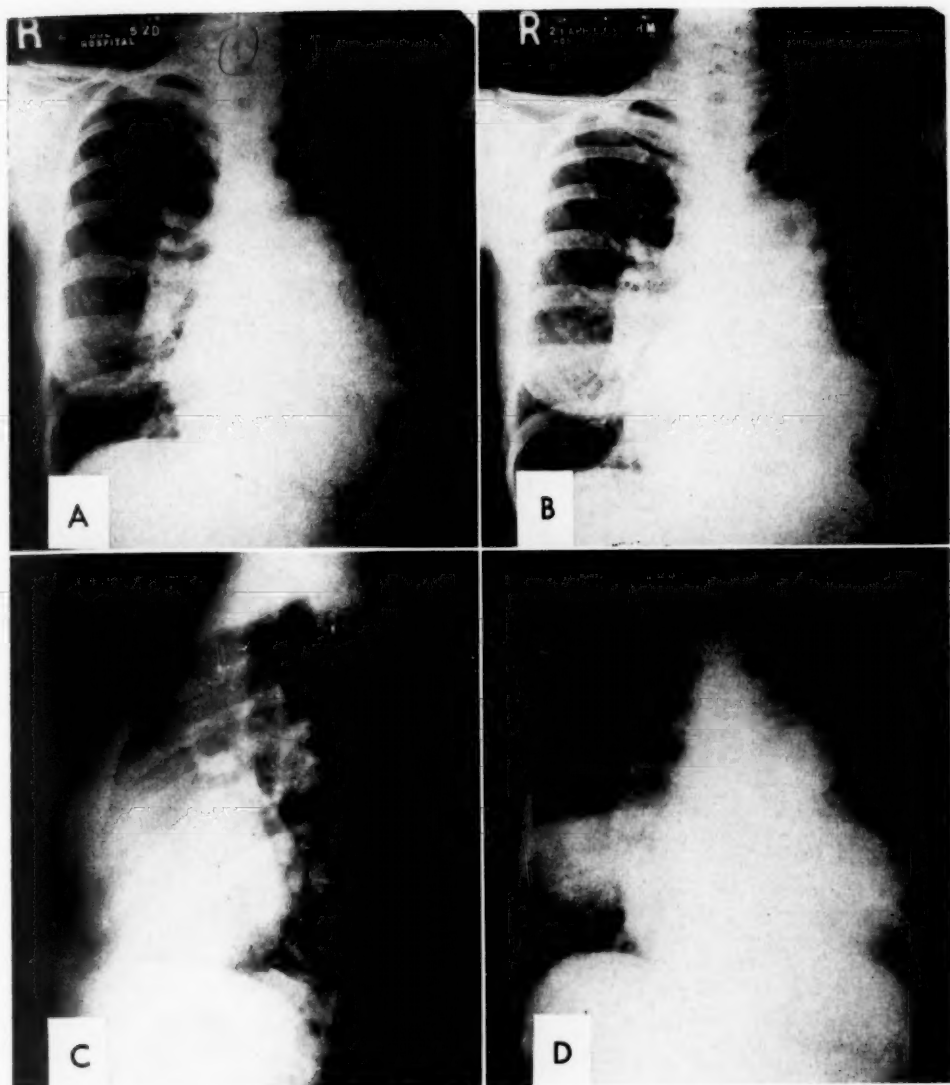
(A) Preoperative x-ray of chest showing dilatation of pulmonary artery and branches. (B) and (C) Posteroanterior and left lateral films 7 months postoperatively showing aneurysm at site of ductus. (D) Film taken eight months postoperatively showing opacity in right lung due to mycotic aneurysm of a branch of the pulmonary artery.
